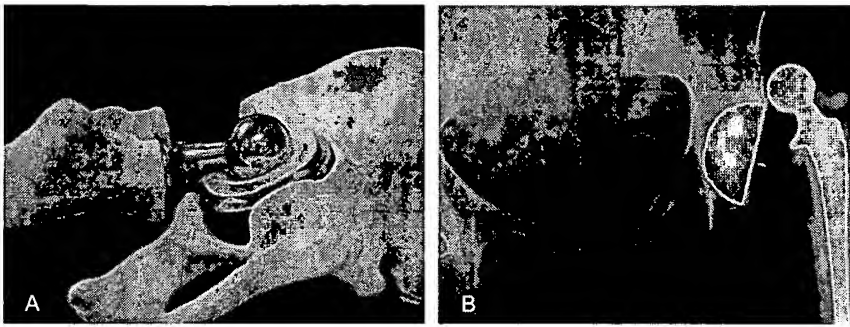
A. Prosthetic femoral implant (*above*) and acetabular cup (*below*) for total hip replacement surgery. B. X-ray showing dislocated prosthetic components in hip. (A. from Moody JE, DiGioia AM, Jaramaz B, Blackwell M, Golgan B, et al. 1998. Gauging clinical practice: surgical navigation for total hip replacement. In *Proc. Med. Image Computing and Comp.-Assisted Intervention, Cambridge, Mass*, ed. WM Wells, A Colchester, S Delp. Cambridge, MA, p. 421. Berlin: Springer-Verlag. Reprinted with permission. B. from Simon DA, Jaramaz B, Blackwell M, Morgan F, DiGioia AM, et al. 1997. Development and validation of a navigational guidance system for acetabular implant placement. In *Proc. Comp. Vis., Virtual Reality Robotics Med., Med. Robotics Comp.-Assisted Surg., 1st, Grenoble, France*, ed. J Troccaz, E Grimson, R Mosges, p. 583. Berlin: Springer-Verlag. Reprinted with permission.)
